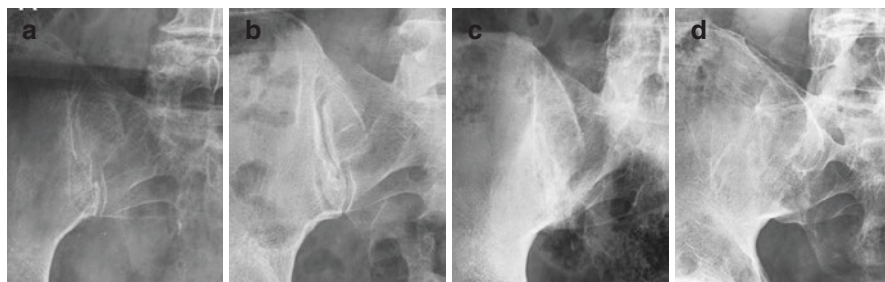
Grading of radiographic sacroiliitis
